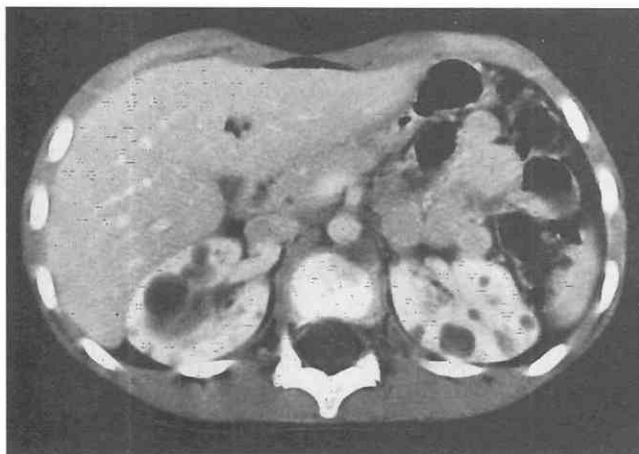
Autosomal dominant polycystic kidney disease in an 8-year-old girl. Contrast-enhanced CT axial image through the kidneys. Innumerable cysts are present throughout both kidneys, surrounded by normally enhancing renal parenchyma.
